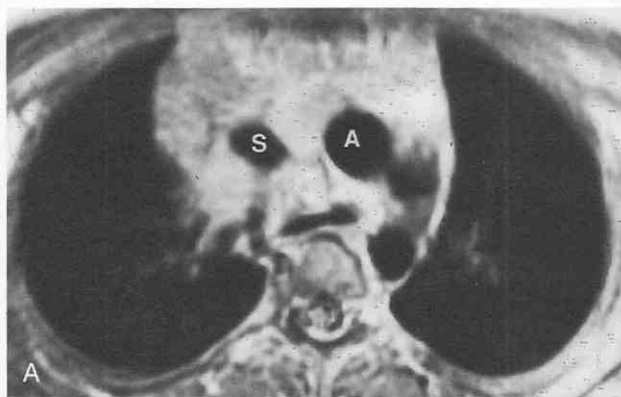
Nodular sclerosing Hodgkin's lymphoma. T1-weighted MR image (A) shows a lobular, heterogeneous anterior mediastinal mass with intermediate signal intensity. T2-weighted MR images (B and C) show the mass to have heterogeneous signal intensity. On a cephalic image (B), there are areas of decreased signal intensity consistent with intratumoral fibrosis. On a caudal image (C), the mass predominantly shows high signal intensity, similar to subcutaneous fat. A, aorta; S, superior vena cava. (Reprinted with permission from Erasmus JJ, McAdams HP, Donnelly LF, Spritzer CB: MR imaging of mediastinal masses. *Magn Reson Imaging Clin North Am* 8:59-89, 2000.)
